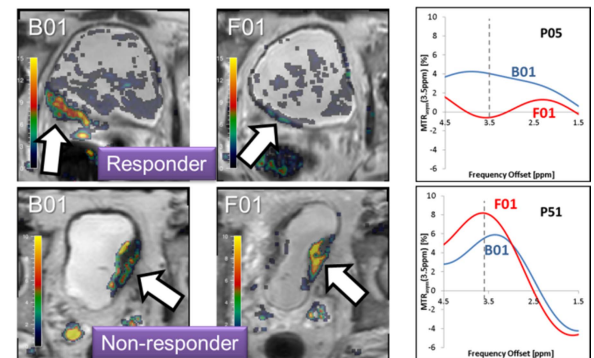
Typical baseline and mid-cycle APT-MRI scans from a chemotherapy responder and a non-responder.
